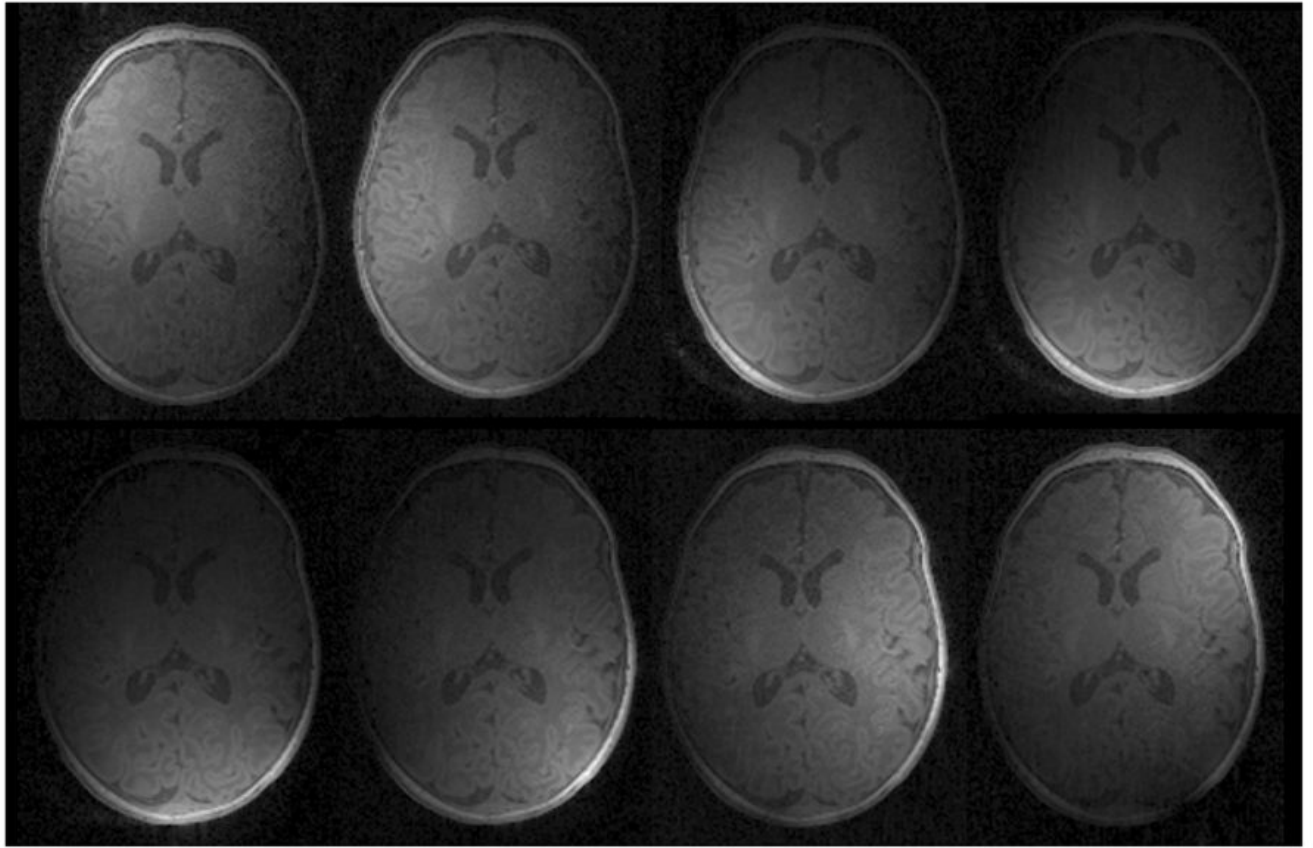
Eight T1 MR images obtained from the eight phased array coil elements. Each image has different sensitivity region, corresponding to the individual location of each coil.
